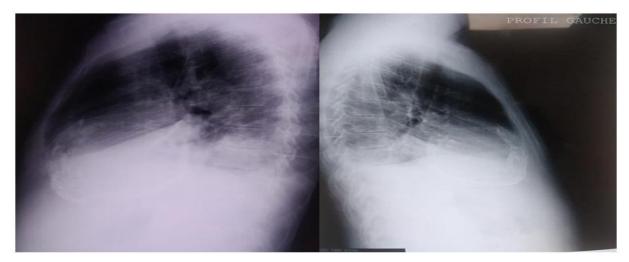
X-ray of the left and right chest showing calcification of the pericardium
